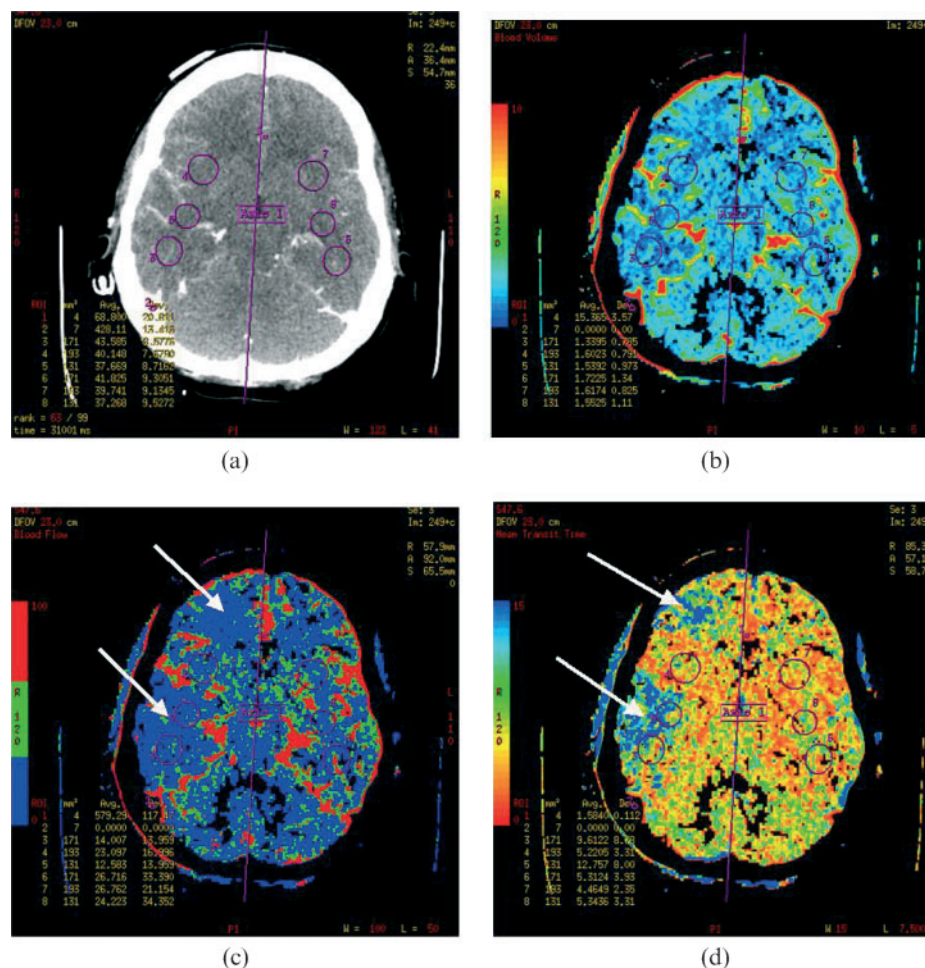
(a–d) Assessment of vasospasm. A previously fit and well female presented with acute subarachnoid haemorrhage. She was stable with no focal defect; at the time the causative right middle cerebral artery aneurysm was coiled endovascularly. Two days later she developed a left hemiparesis. The clinical diagnosis was of likely vasospasm but CT perfusion was requested to determine tissue viability. (a) CT from CT perfusion study with regions of interest in the affected and unaffected hemisphere for comparison. There was no evidence of ischaemia on plain CT. (b) Cerebral blood volume (CBV) map shows no deficit. (c) Cerebral blood flow (CBF) map shows a slight reduction in blood flow in the right frontal lobe and more severe reduction in the temporal lobe (arrows). (d) Mean transit time (MTT) map. There are reasonably well-circumscribed areas of prolonged MTT up to 12 s that conform to vascular territories of the right middle cerebral artery. Interpretation: the prolonged MTT, with normal blood volume and reduced blood flow (a function of time) is indicative of vasospasm. The CBF parameters show that cerebral tissue is not irreversibly ischaemic. However, parameters in the right temporal lobe suggest that unless the spasm is relieved and/or blood flow increased, infarction may ensue. The patient was aggressively treated with haemodilution, hyperhydration and hypertensive (HHH) therapy and eventually made a full recovery.
